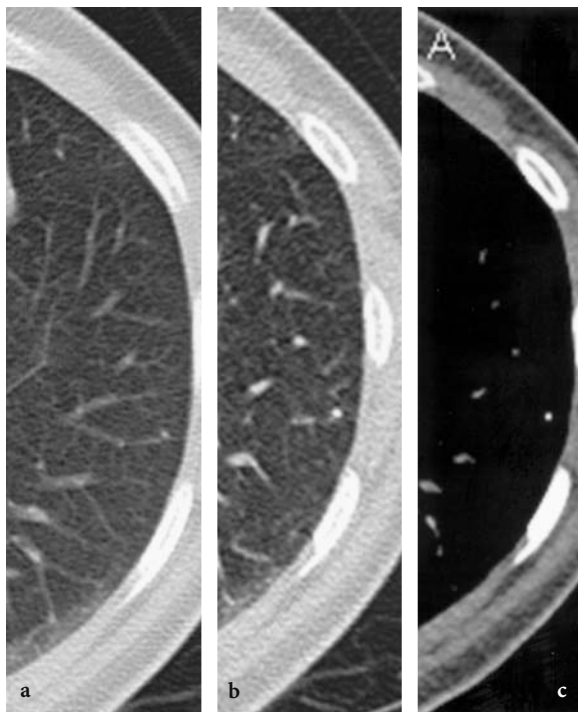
Effect of thin versus thick CT sections: calcified granuloma. a A 7 mm target reconstructed section through the left mid lung shows a small (3 mm) nodule in the lung periphery. b, c 1 mm target reconstructed section at the same level as in a imaged with wide and narrow windows, respectively. Note that the lesions is now considerably more conspicuous and clearly calcified
